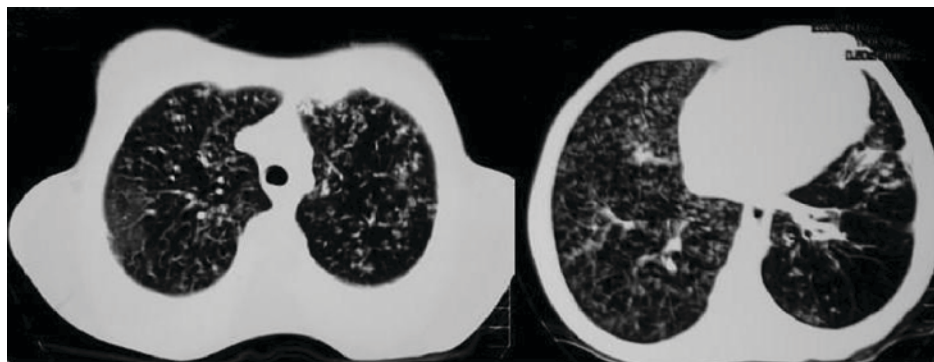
HRCT images. Diffusive reticulonodular involvement in the lungs and ground-glass appearance in the peripheral areas on the HRCT sections taken from various slices.
